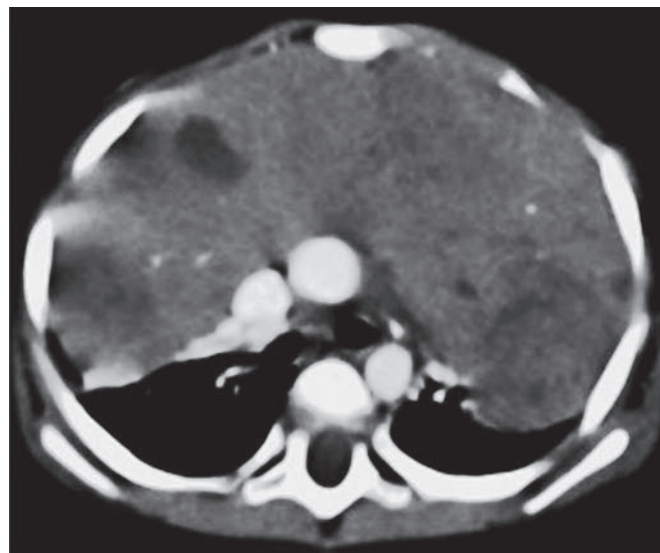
CT scan showing massive mediastinal mass ($15.2 \times 11.2 \times 8.8$ cm) originating from the thymus and filling the whole thoracic cavity.
